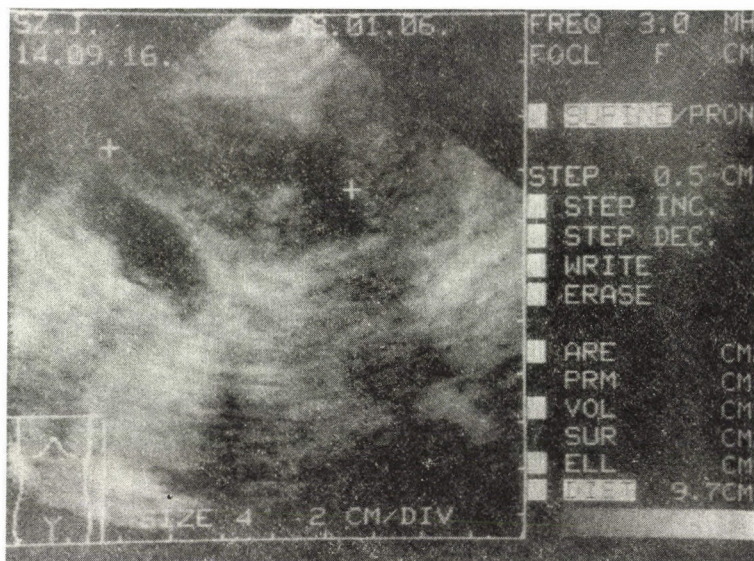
Sonogram (06, 1, 1988). On the border of the two lobes, anterior to the gallbladder, but mainly in the right lobe, an inhomogeneous region, about 10 cm in diameter containing also not distinctly differentiable cystose parts can be seen. A somewhat larger than normal thick-walled gallbladder with several echodense structures and acoustic shadows
